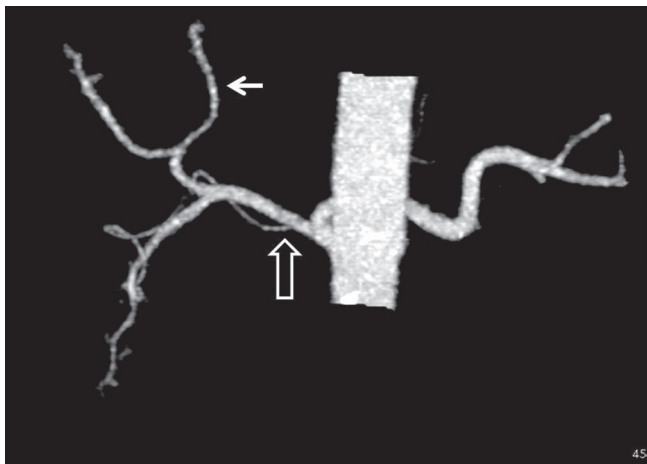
Maximum intensity projection images of a 62-year-old gentleman who underwent computed tomography angiogram for peripheral arterial occlusive disease showing left hepatic artery supplying segment 4 of the liver. Solid arrow – left hepatic artery and open arrow – common hepatic artery.
